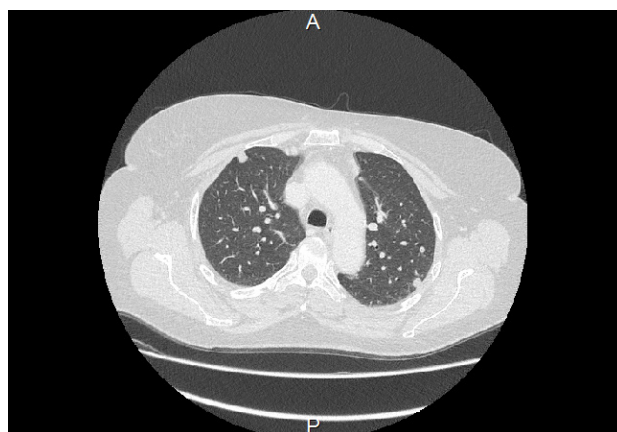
Chest CT, axial view - multiple mass lesions with a polycycle outline mostly in the periphery of both lungs.
